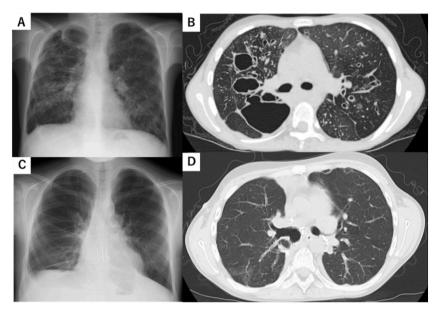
Chest radiograph and CT images before and after bilateral lobar lung transplantation. (A) Preoperative radiograph and (B) CT image showing multiple pulmonary cysts. (C) Radiograph and (D) CT image 6 months after lung transplantation showing no abnormalities in either graft. CT, computed tomography.
